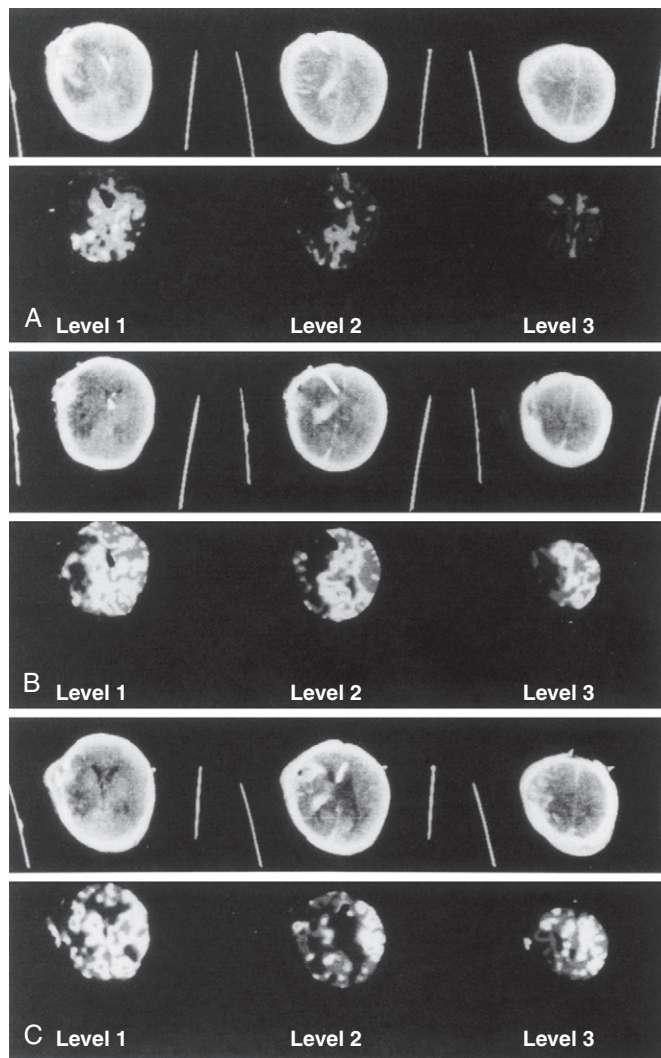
Time course of CBF measured by Xe-enhanced CT in a 2-month-old infant after severe traumatic brain injury from a motor vehicle accident. Standard CT images (*upper row*) and Xe-enhanced CBF maps (*lower row*) are shown from studies performed on admission (A) and at 2 days (B) and 5 days (C) after injury. Flow is severely reduced (*black*) on admission. Some recovery of CBF is seen at 2 days and 5 days after injury. CBF ranges from lowest (*darkest image*) to highest (*brightest image*).
